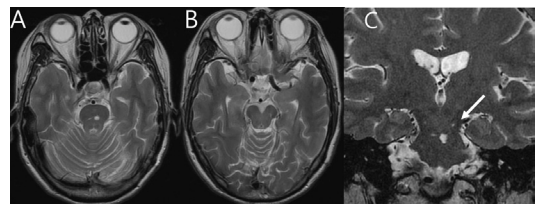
Magnetic resonance imaging (MRI) 1 year after surgery showed small encephalomalacia in the left medial pons (Fig. 3A) and the left substantia nigra (Fig. 3B) with the coronal image (Fig. 3C)
